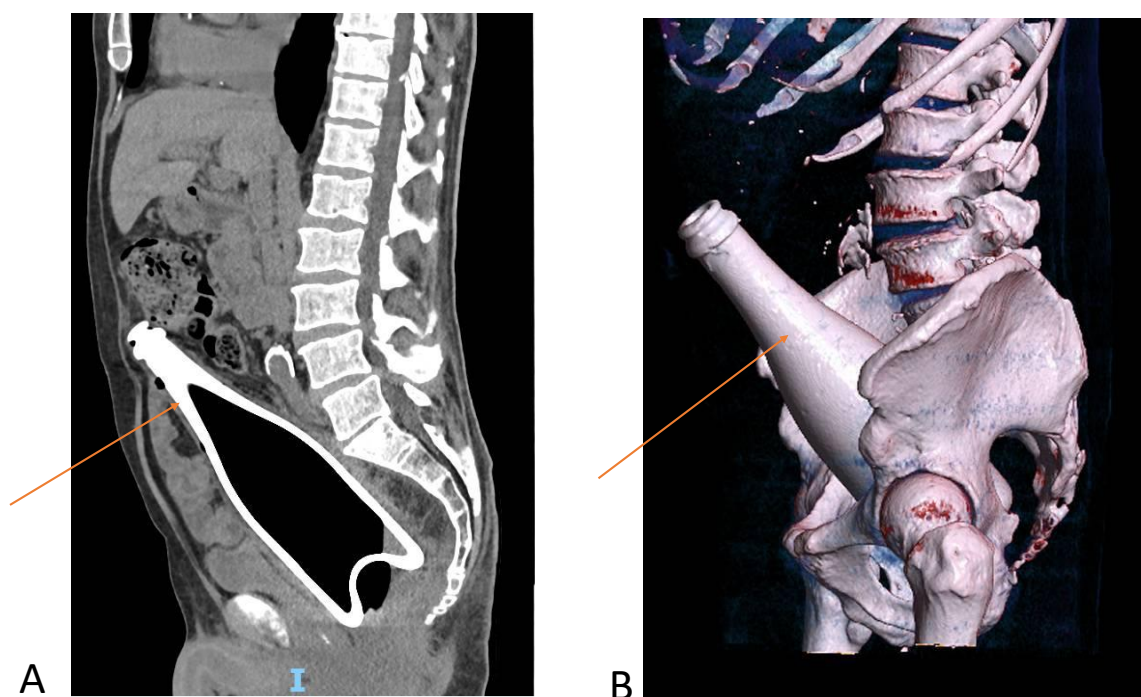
(Case 2) Computed tomography (CT) assessment of a proximally migrated glass bottle. (A) Sagittal unenhanced CT image revealing a hyperdense, bottle-shaped structure with predominantly aerated content lodged at the rectosigmoid junction (arrows). (B) Multiplanar reconstruction (MPR) detailing the precise anatomical lie and proximal extension of the object within the pelvic cavity
